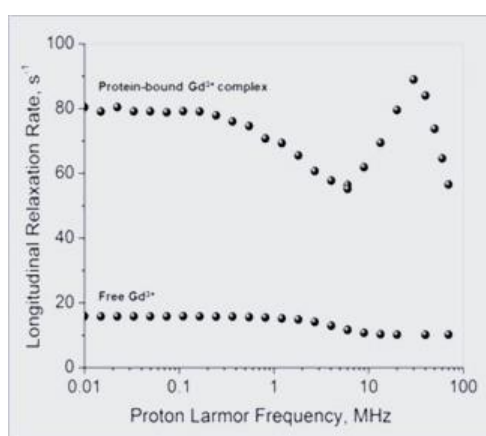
NMRD profile of Gadolinium complex for MRI contrast agent.
